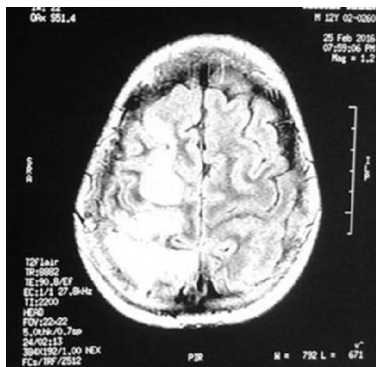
MRI brain hyperintensities in T2 involving multiple lobes suggestive of hemorrhagic infarction at (R) fronto-parietal and (L) parieto-occipital lobe
